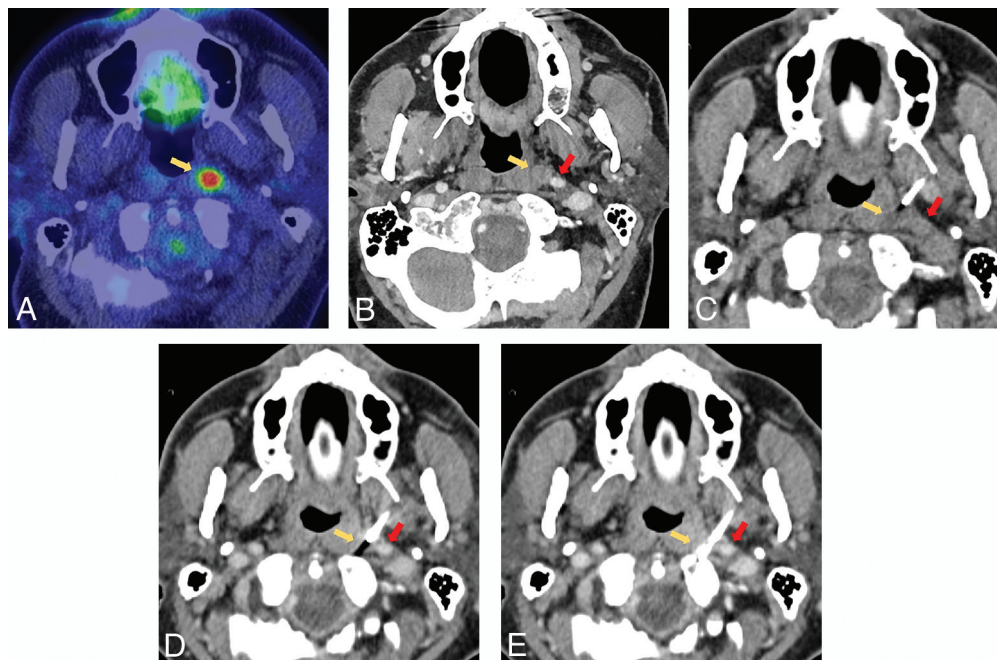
A, PET/CT with hypermetabolic left retropharyngeal 6-mm lymph node (yellow arrow). B, This lesion is centrally cystic/necrotic on follow-up contrast-enhanced CT (yellow arrow) and immediately medial to the ICA (red arrow). C, Intraprocedural CT without contrast with an 18-ga needle advanced via a paramaxillary approach anterior to the target retropharyngeal lymph node (yellow arrow) and medial to the expected location of the unopacified ICA (red arrow). Before further needle advancement, 60 mL of Omnipaque-300 was slowly infused at a rate of 0.6 mL/s to continuously opacify the ICA (red arrows) for adequate visualization before (D) and during (E) lesion sampling (yellow arrows). Pathology reported poorly differentiated metastatic carcinoma in a patient with a history of oropharyngeal human papillomavirus + SCC.
